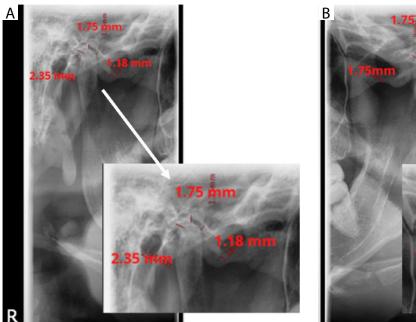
Axis placed in the middle of the condyle in cone-beam computed tomography image reconstruction for joint space measurement according to Ikeda and Kawamura's method [9]. A) Axial view with the widest medial-lateral diameter of condyle. B) Sagittal view
